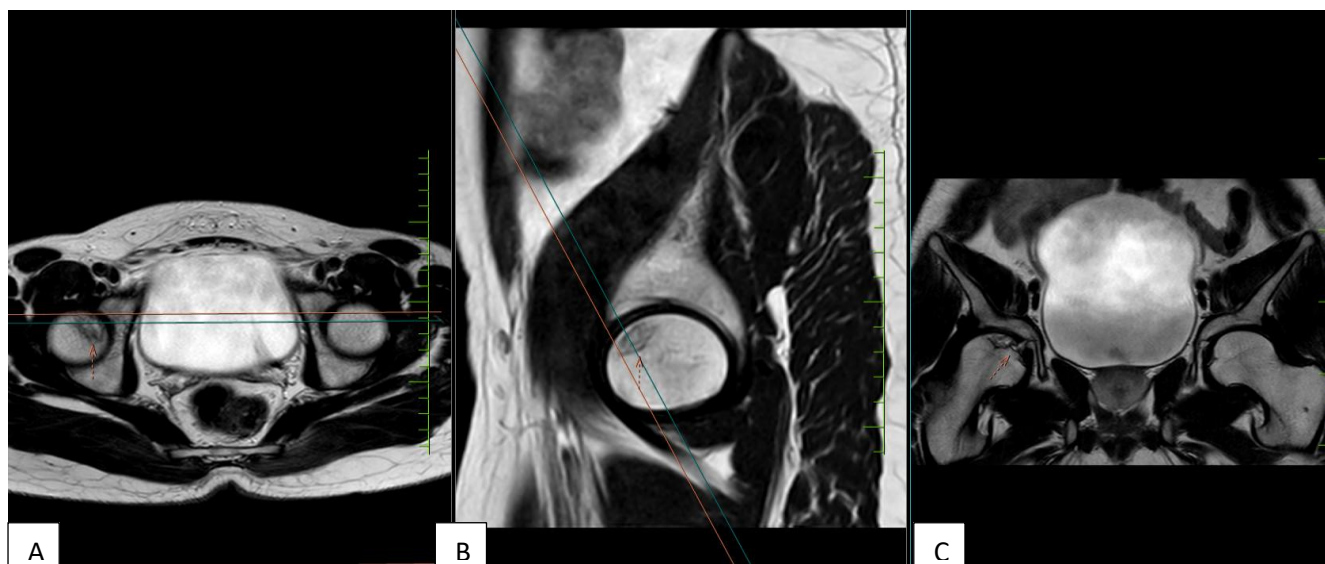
(A-C): MRI images of right hip joint demonstrating joint space narrowing and osteonecrotic changes in right femoral head (yellow circles).
